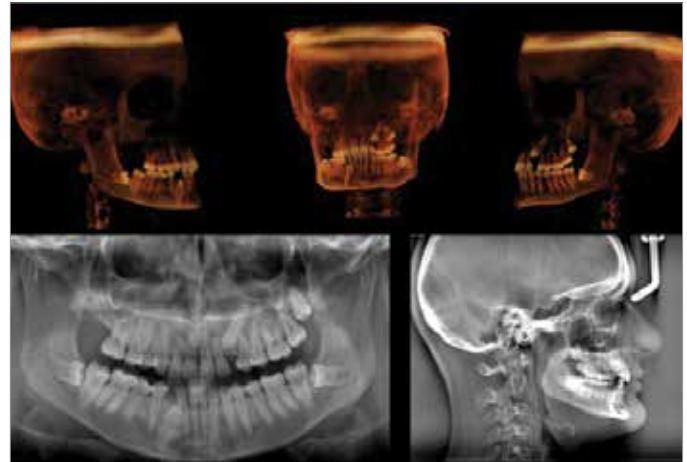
3D cone beam computerized tomography (CBCT) image and 2D panoramic and lateral cephalometric radiography of a patient with impacted teeth
